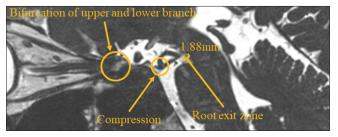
Preoperative sagittal heavily T2-weighted magnetic resonance image showing neurovascular compression on the peripheral side of the root exit zone.
